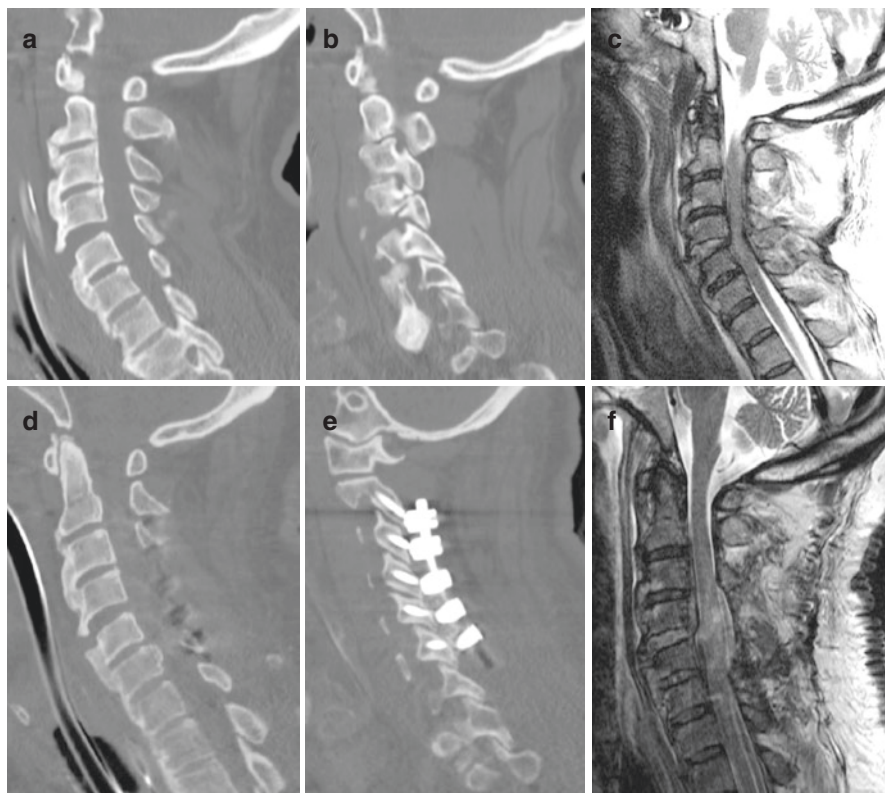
76-year-old male with DISH after a fall downstairs while intoxicated resulting in central cord injury. (a) Sagittal CT demonstrating widening of the C4-C5 disc space and acute fracture through the overlying osteophyte, which (b) extends posteriorly into the lamina and facet. (c) Sagittal T2 MRI with intramedullary hyperintensity at C4-C5, C3-C6 severe stenosis with ventral epidural hematoma. (d) Postoperative sagittal CT demonstrating posterior decompression and (e) lateral mass instrumentation. (f) Postoperative sagittal T2 MRI with decompressed cord and evolution of cord edema
